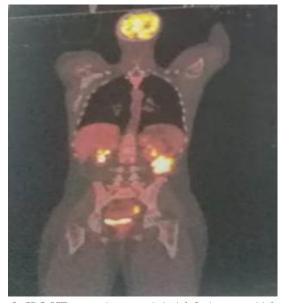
FDG PET intense hypermetabolic left flank mass and left scrotal fixation mass.
